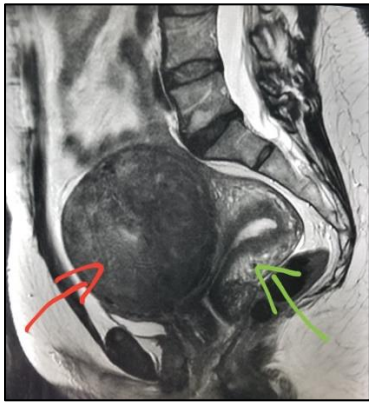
MRI image of cervical fibroid.
